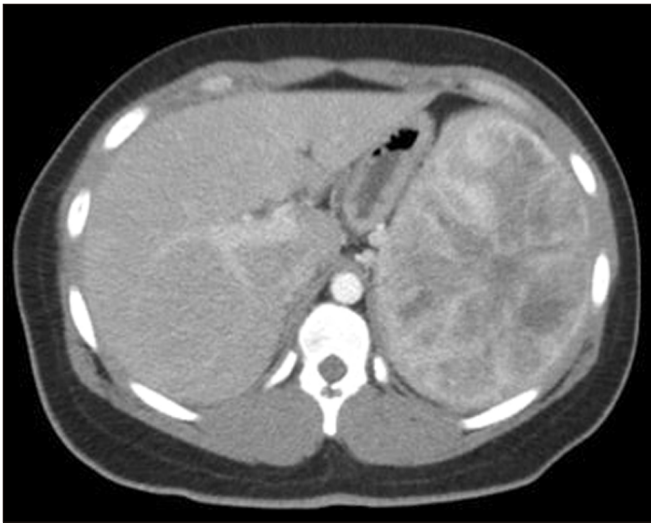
Early contrast-enhanced helical computed tomography scan showing enlarged spleen containing innumerable small, focal, low-density lesions.
